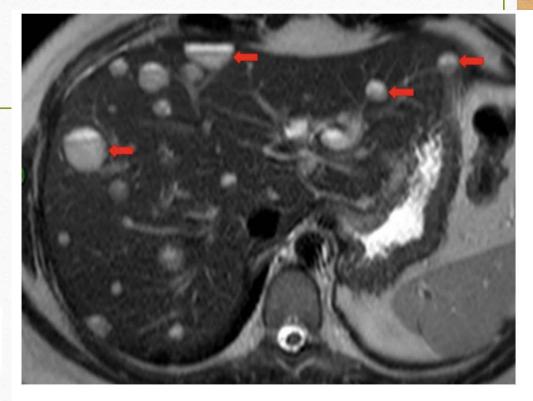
Axial T2-weighted MR image showing multiple hyperintense cystic lesions (arrows), corresponding to intrahepatic bile duct dilatations in a patient with Caroli disease.
